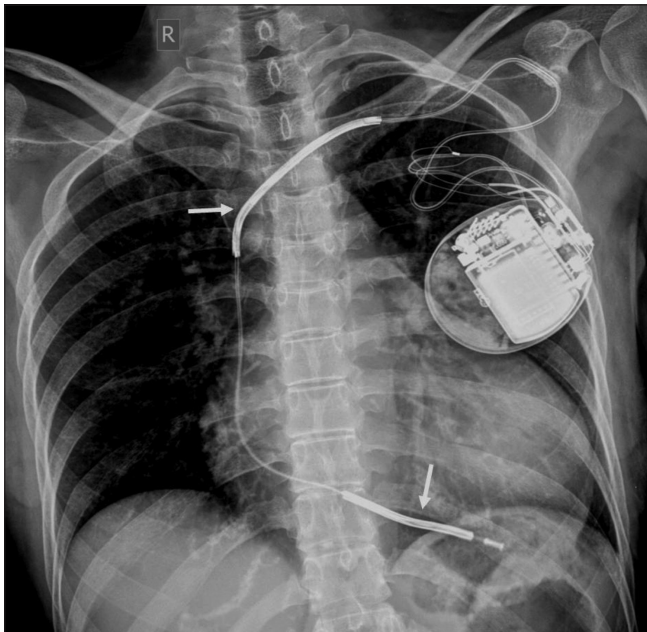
Frontal chest radiograph of a patient with automated implantable cardioverter defibrillator. Dense bands (arrows) along the electrode are characteristic of this device
